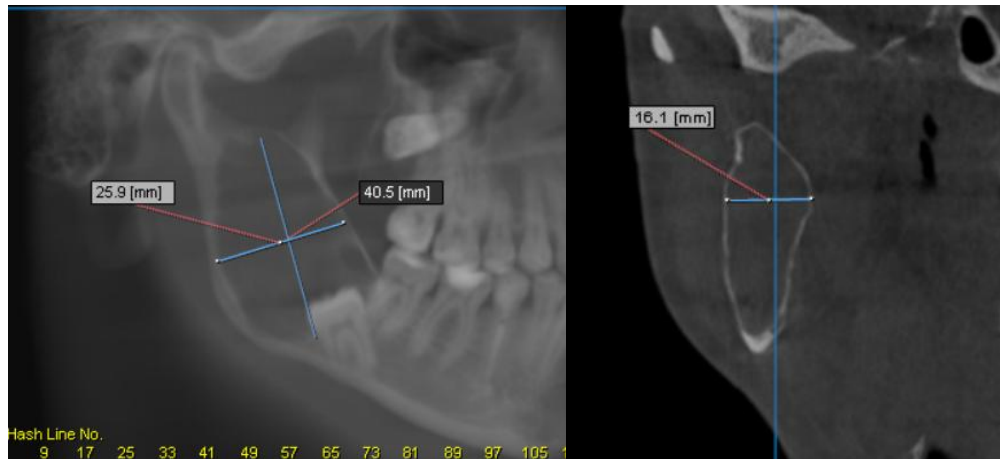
Assessment of cystic lesion volume using CBCT
